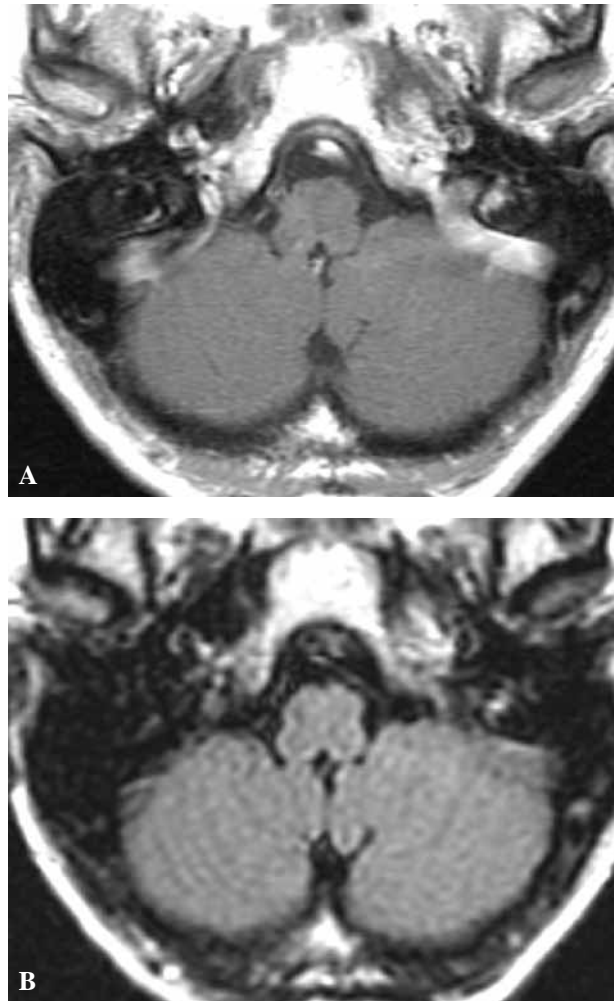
Post-treatment MR status at 2 months. 3A & B: similar slice location and weightings as in Figures 1A and 1B showing complete resolution of the medullar abnormalities; 3A. Post-contrast T1-weighted image showing disappearance of any abnormal contrast-enhancement within the parenchyma; 3B. FLAIR image showing normalization in size and signal intensity of the medulla oblongata.
